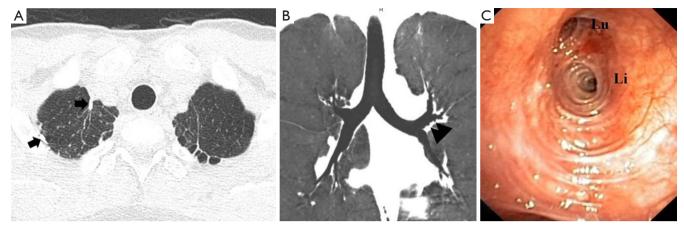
(A) Thin-section axial CT scan of the chest with lung-window setting showing multiple small residual subpleural blebs/bullae at the left lung apex. Note fibrotic scarring at the bilateral lung apices and several staples (arrow) at the right apex as a result of prior thoracotomies; (B) coronal CT image of the tracheobronchial tree obtained with minimum intensity projection technique and lung window setting showing multiple tiny diverticula (arrowheads) arising from the left upper lobe bronchus and its segmental bronchi; (C) bronchoscopy revealing bronchial diverticulosis, seen as multiple tiny dimples or mucosal depressions in the left upper lobe bronchus and at the origins of its upper division (Lu) and lingular bronchus (Li).
